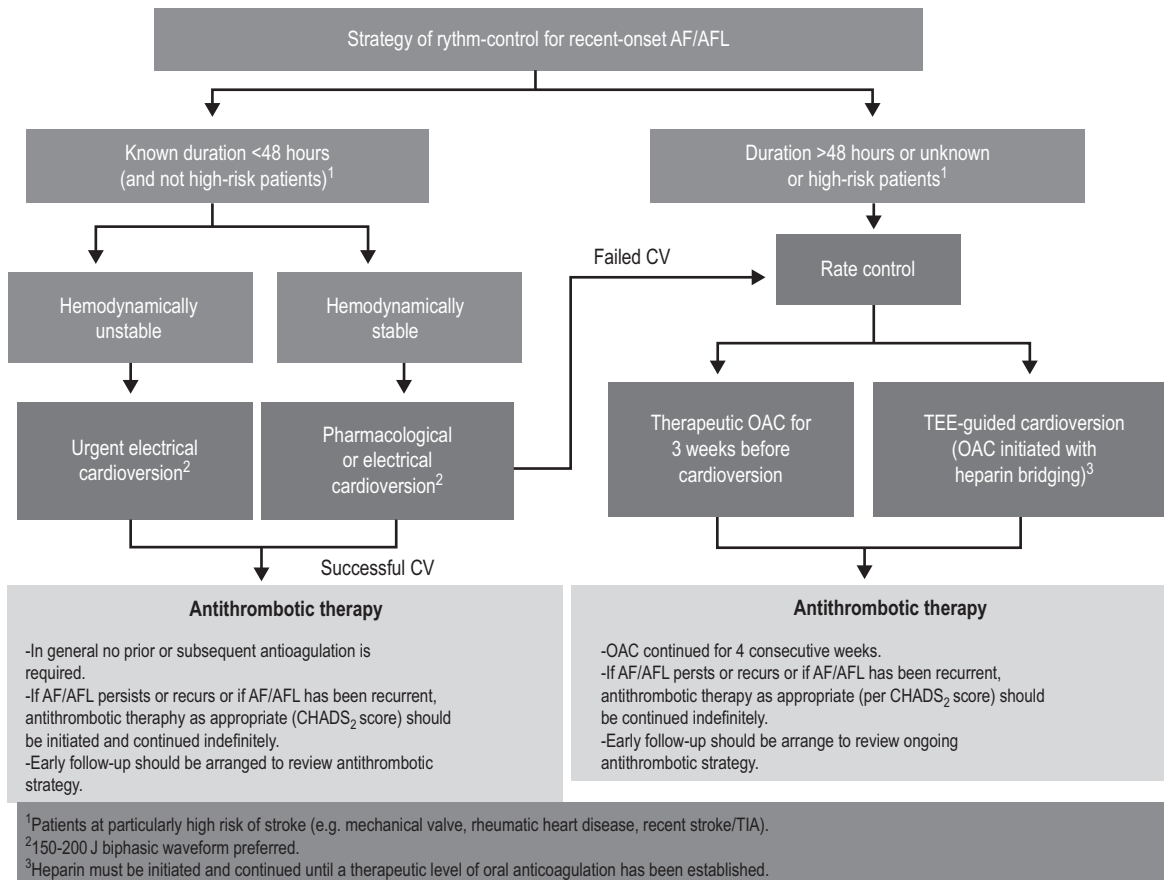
Management algorithm for atrial fibrillation (AF) in the emergency department. AFL, atrial flutter; CV, cardioversion; OAC, oral anticoagulation; TEE, transoesophageal echo; TIA, transient ischaemic attack. (Reproduced with permission from Stiell IG, Macle L, CCS atrial fibrillation guidelines committee. Canadian cardiovascular society atrial fibrillation guidelines 2010: management of recent onset atrial fibrillation and flutter in the emergency department. *Can J Cardiol.* 2011; 27:38–46.)
